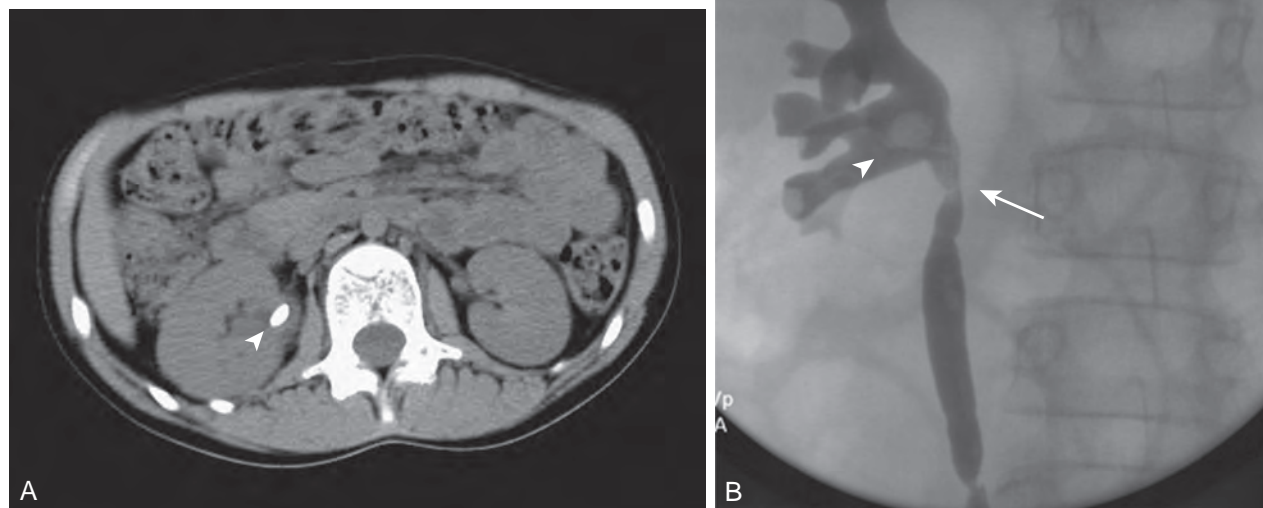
Computed tomography scan (A) and retrograde pyelogram (B) in a 10-year-old girl with glucose transport deficiency demonstrating a 9-mm renal pelvic stone (*arrowheads*). Nephrolithiasis was secondary to profound hypocitruria and hypercalciuria. Primary ureteroscopy could not be accomplished because of a narrowed segment of proximal ureter (*arrow*). After 8 weeks of ureteral accommodation with an indwelling stent, flexible ureteroscopy with laser lithotripsy and stone basketing was performed.
